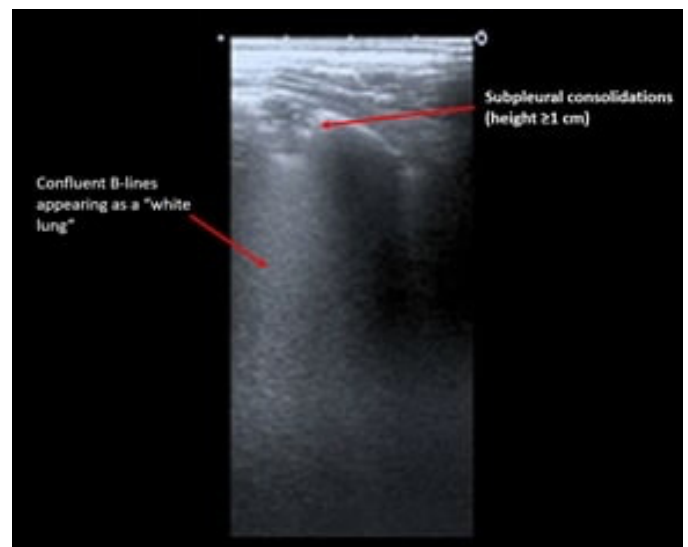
Abnormal lung ultrasound image (score 3) with confluent B-lines appearing as a “white lung” and subpleural consolidations (height \geq 1 cm)
